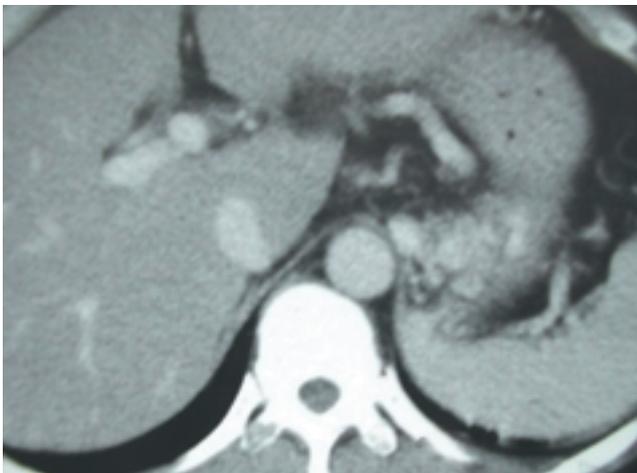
Contrast enhanced abdomen CT shows dilated gastric varices.
